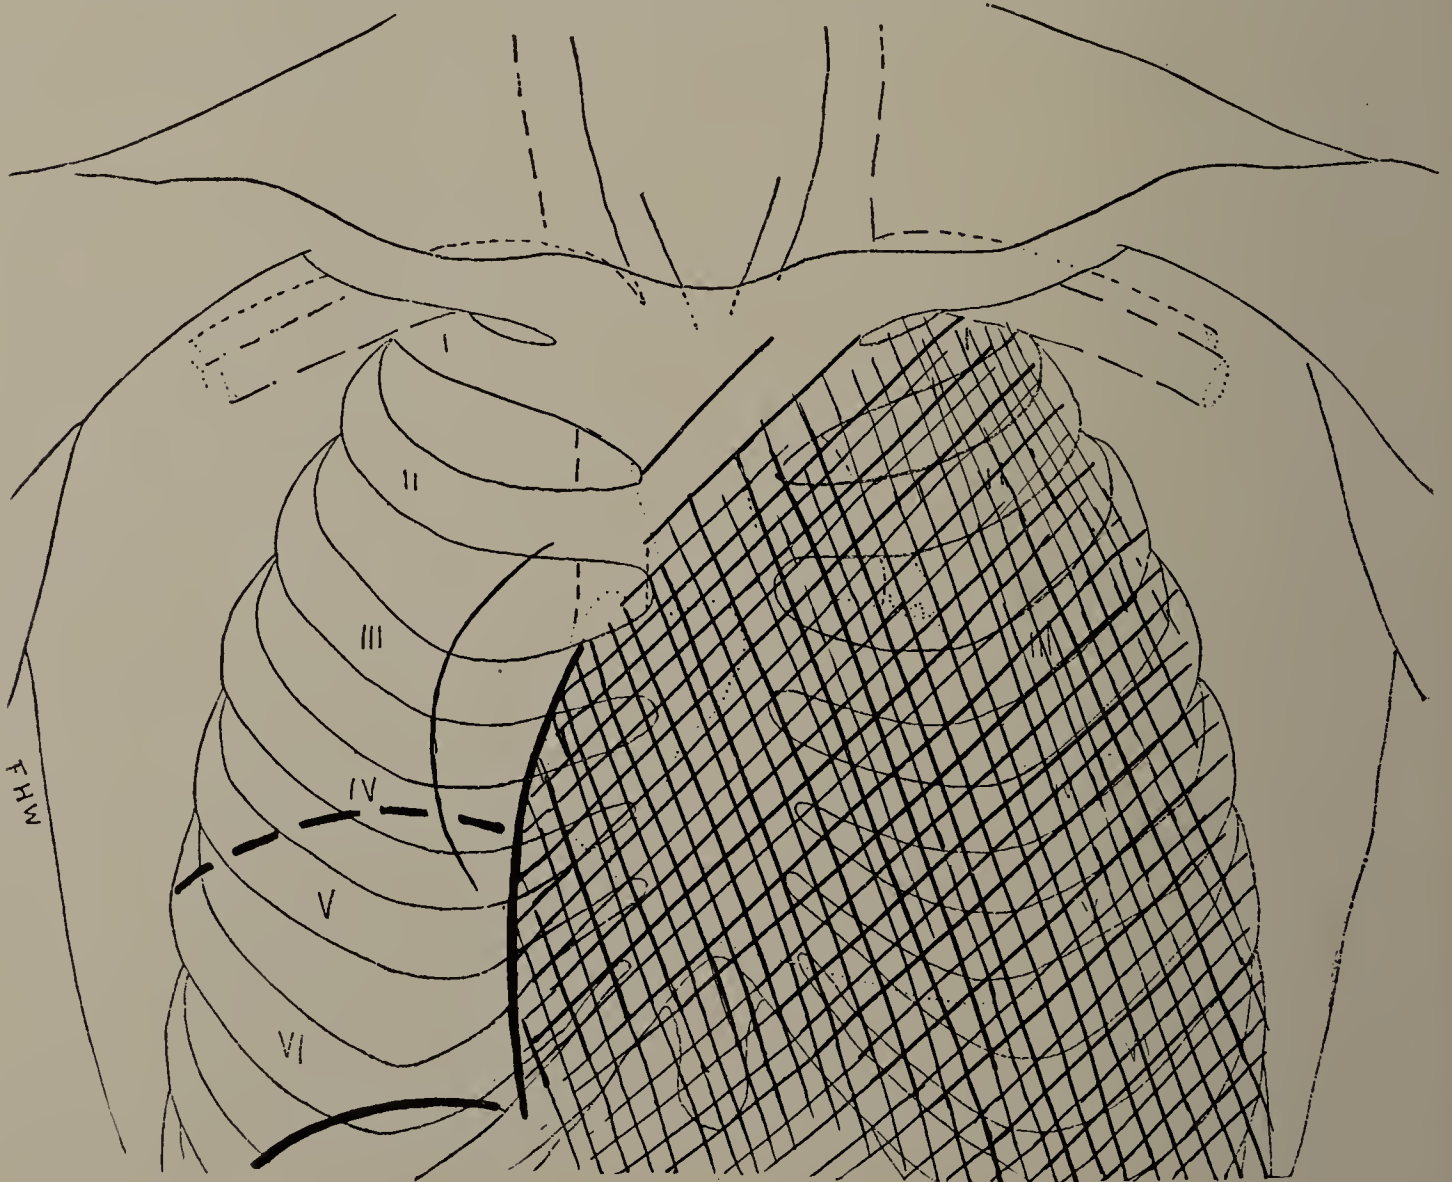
Thomas R. March 12, 1897. Pleurisy with effusion. First X-ray examination with screen. Whole of left chest dark; first and second ribs seen faintly; heart displaced to right. (Cut one-third life size.)
